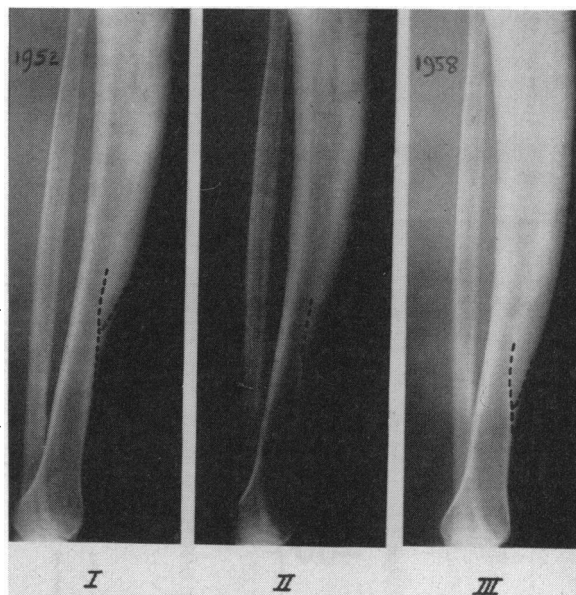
(Case 1).—Paget's disease of left tibia. Serial x-ray films to show progression of lesion (marked in with dotted lines). The numbers I, II and III correspond to Chart 1, showing the dates the films were taken. Note the fissures in the upper third of the tibia in all films in virtually the same location.
